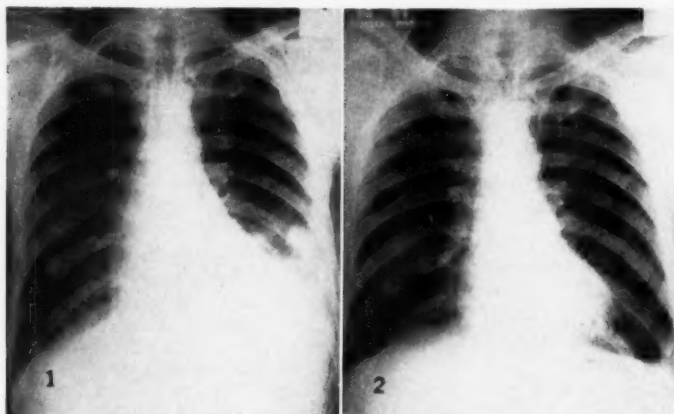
(Case 1). Chest roentgenogram taken on admission (April 19, 1951) showing fluid at the left base.
